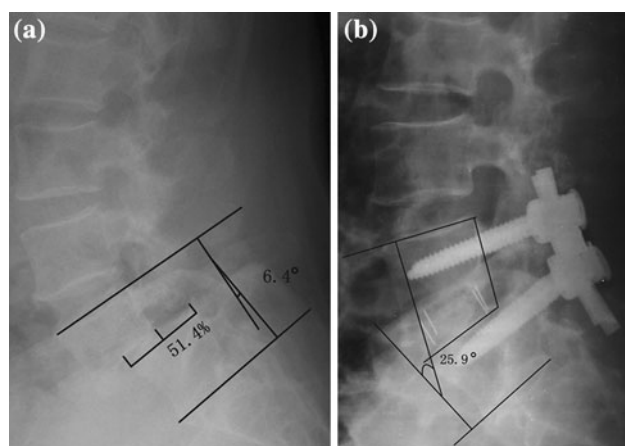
Surgical reduction and PLIF performed in a 52-year-old woman with grade III isthmic spondylolisthesis. Preoperative lateral X-ray showed that slippage was 51.4 % and focal lordosis was 6.4° (a). Postoperative X-ray showed that complete reduction of the spondylolisthesis was obtained and focal lordosis increased to 25.9° (b)
